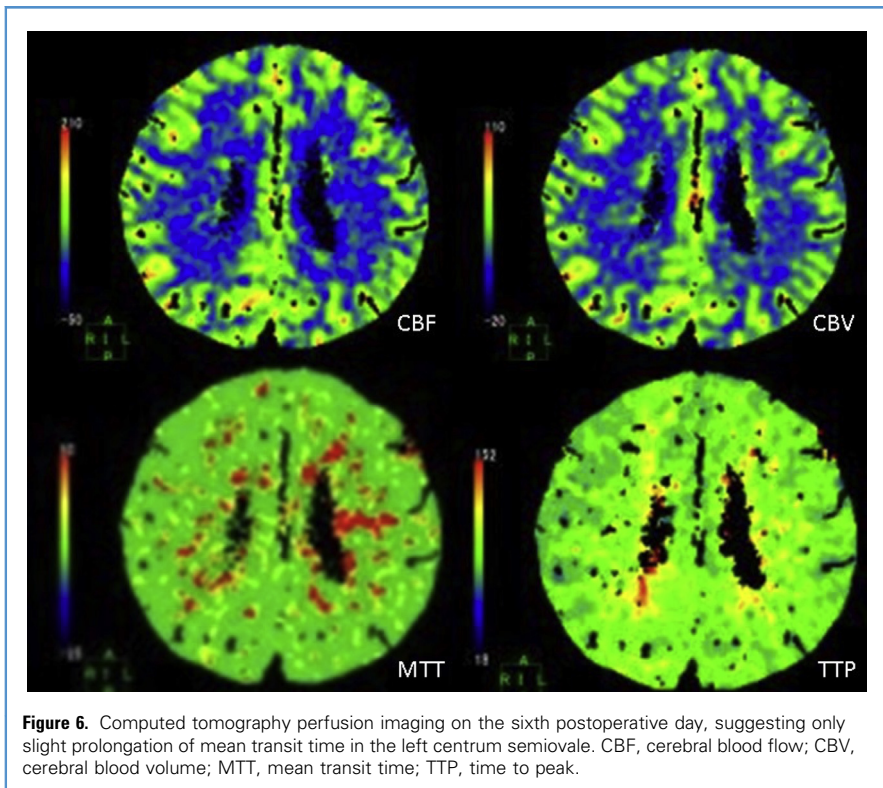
Computed tomography perfusion imaging on the sixth postoperative day, suggesting only slight prolongation of mean transit time in the left centrum semiovale. CBF, cerebral blood flow; CBV, cerebral blood volume; MTT, mean transit time; TTP, time to peak.
